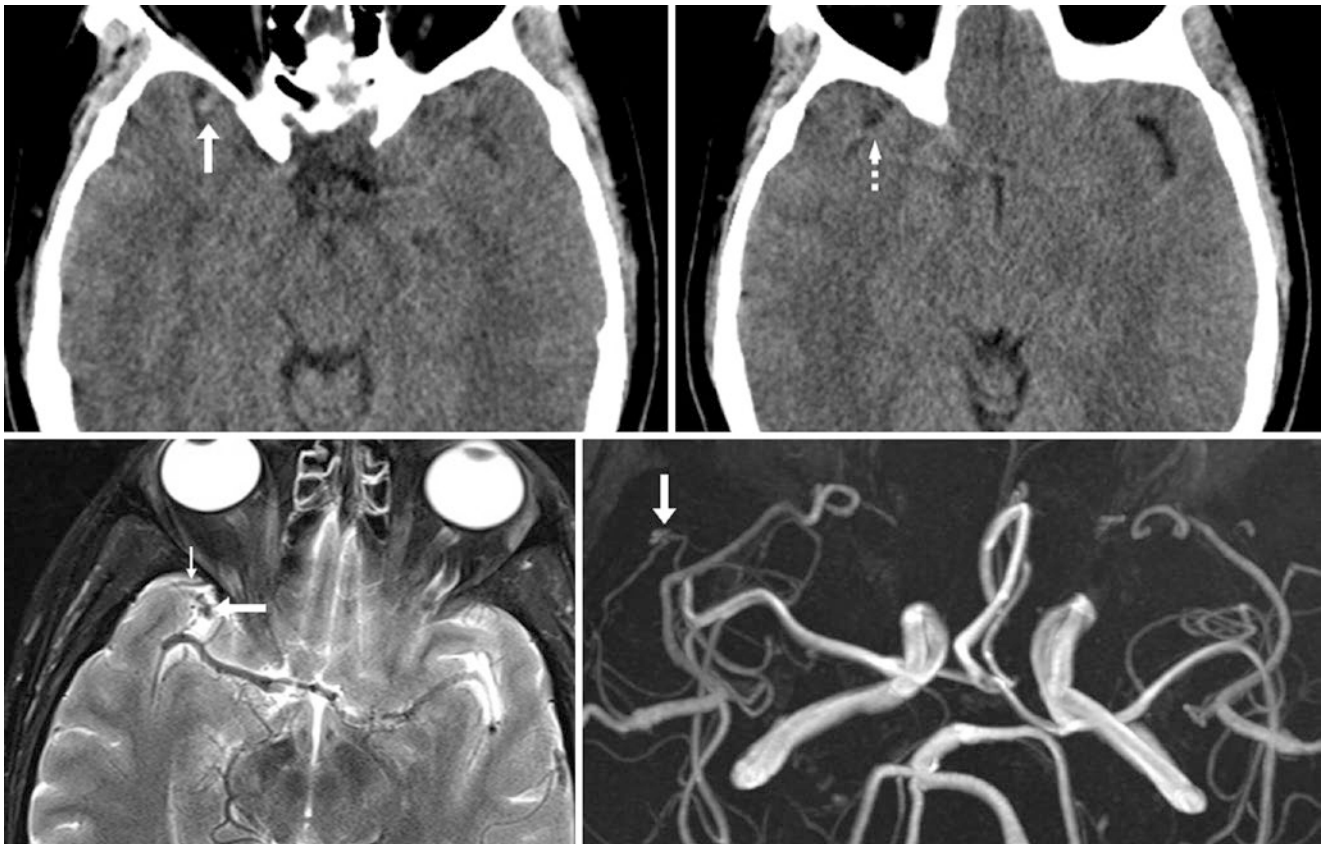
Top row: 49-year-old with a prominent vascular structure (arrow, left) along the inferior aspect of the right MCA (dotted arrow, right) on nonenhanced CT, which raised the question of an MCA aneurysm. Bottom row: MRI and MRA were ordered; T2WI (left) depicted a small flow void from the SMCV (arrow), being anterior to the MCA, with a tiny, normal sphenoparietal sinus (SPS) (thin arrow) just anterior
